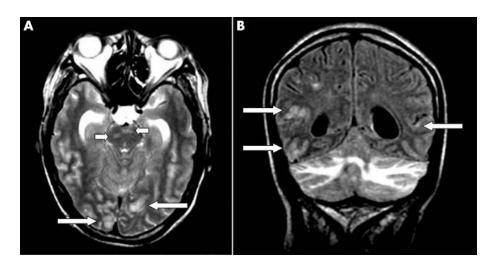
(A) Axial T<sub>2</sub> weighted and (B) coronal fluid attenuated inversion recovery (FLAIR) images showing bilateral abnormal hyperintensities in the white matter of the cerebellum, cortex, and subcortical white matter of the occipital lobes (long arrows), and in the brain stem (short arrows).
